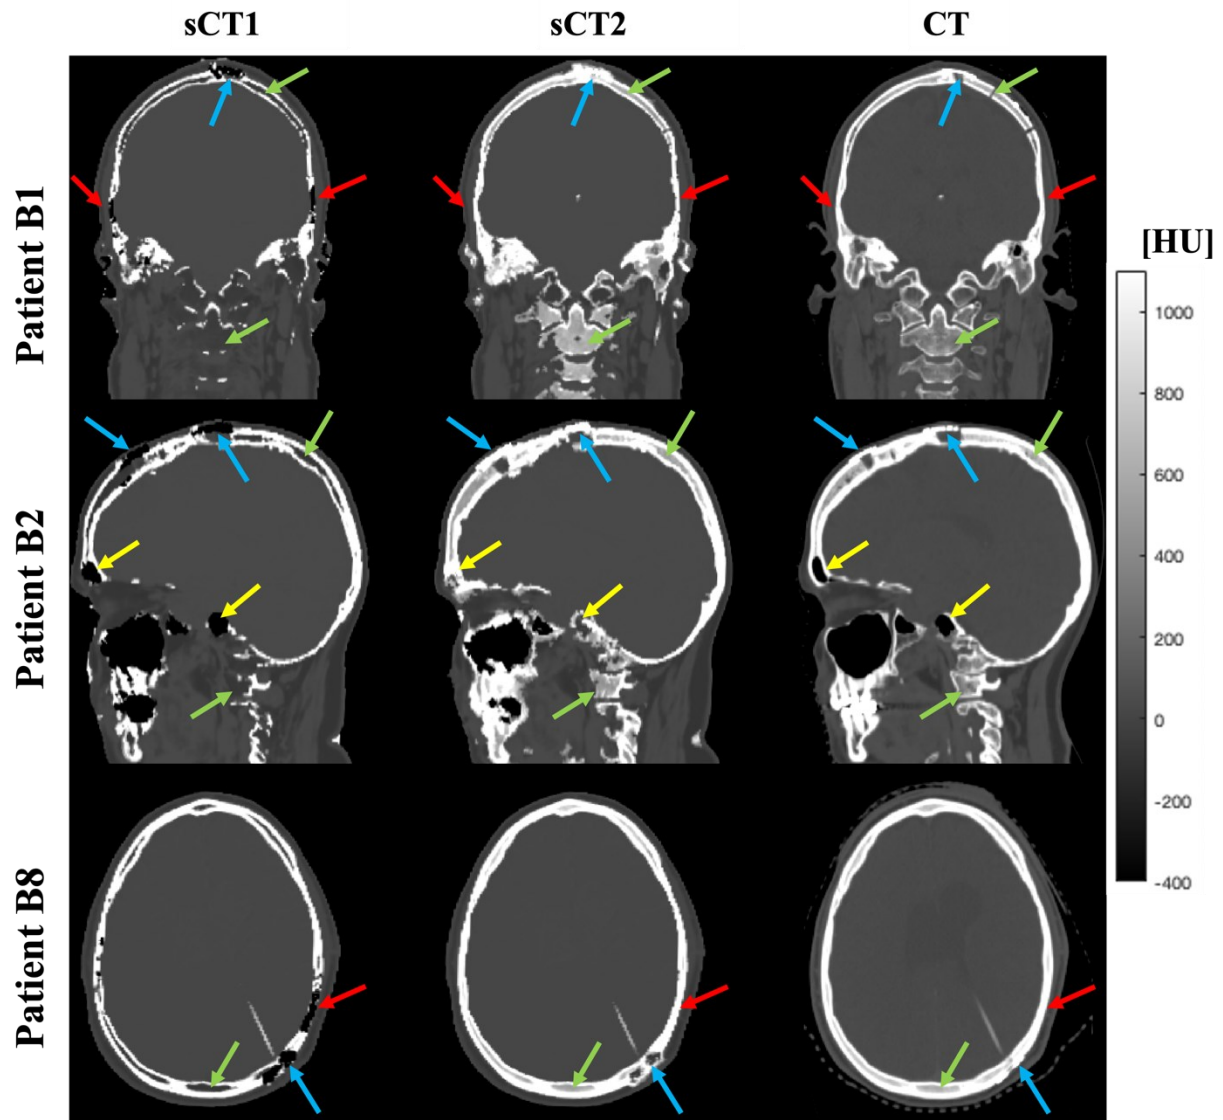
Coronal, sagittal and axial slices of sCT1, sCT2, and CT images for three representative patients. Red arrows: bone erroneously assigned as air in sCT1, but correctly segmented in sCT2. Blue arrows: Ti plates erroneously assigned as air in sCT1, but correctly replaced by Ti in sCT2. Green arrows: trabecular bone assigned as fat in sCT1, but with a more bone-like CT number in sCT2. Orange arrows: air replaced by bone in sCT2.
